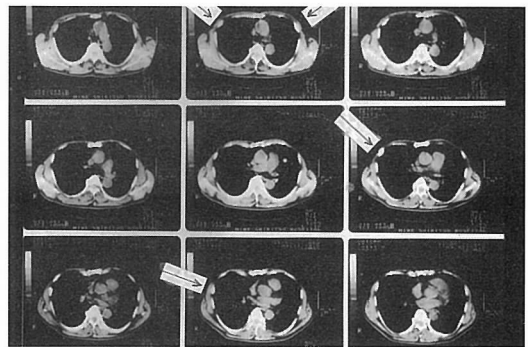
Chest CT also revealed only callus formations corresponding to the plain film lesions without soft-tissue masses or bony destructive changes(→).
